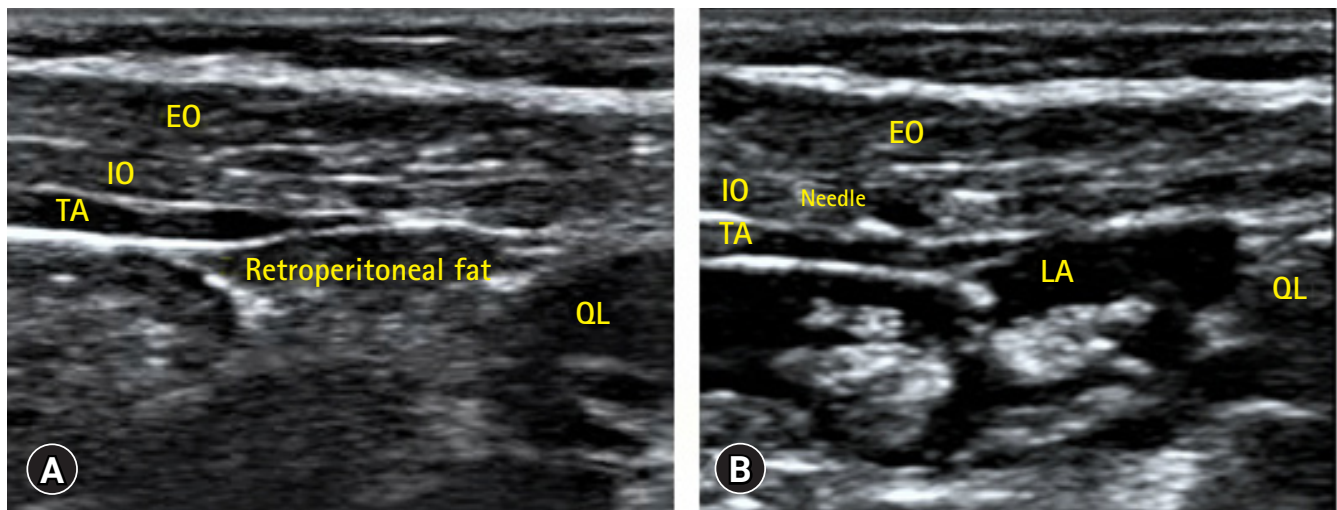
(A) Ultrasound images of transversalis fascia plane before local anesthetic injection. (B) Ultrasound images of transversalis fascia plane after local anesthetic injection. EO: external oblique muscle, IO: internal oblique muscle, TA: transversus abdominis muscle, QL: quadratus lumborum muscle, LA: local anesthetic.
